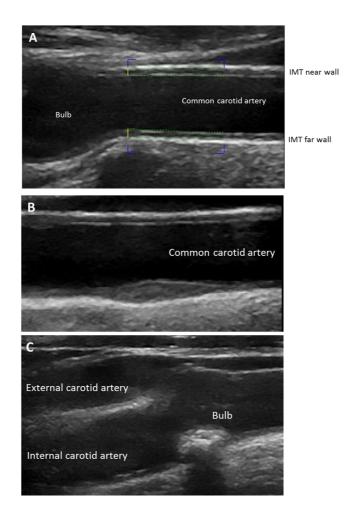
Ultrasonographic measures of carotid atherosclerosis. (A) Intima media thickness (IMT) in the near and far walls of the common catorid artery.(B) Plaque of low echogenicity in the far wall of the common carotid artery. (C) Plaque of high echogenicity in the far wall of the carotid bulb.
